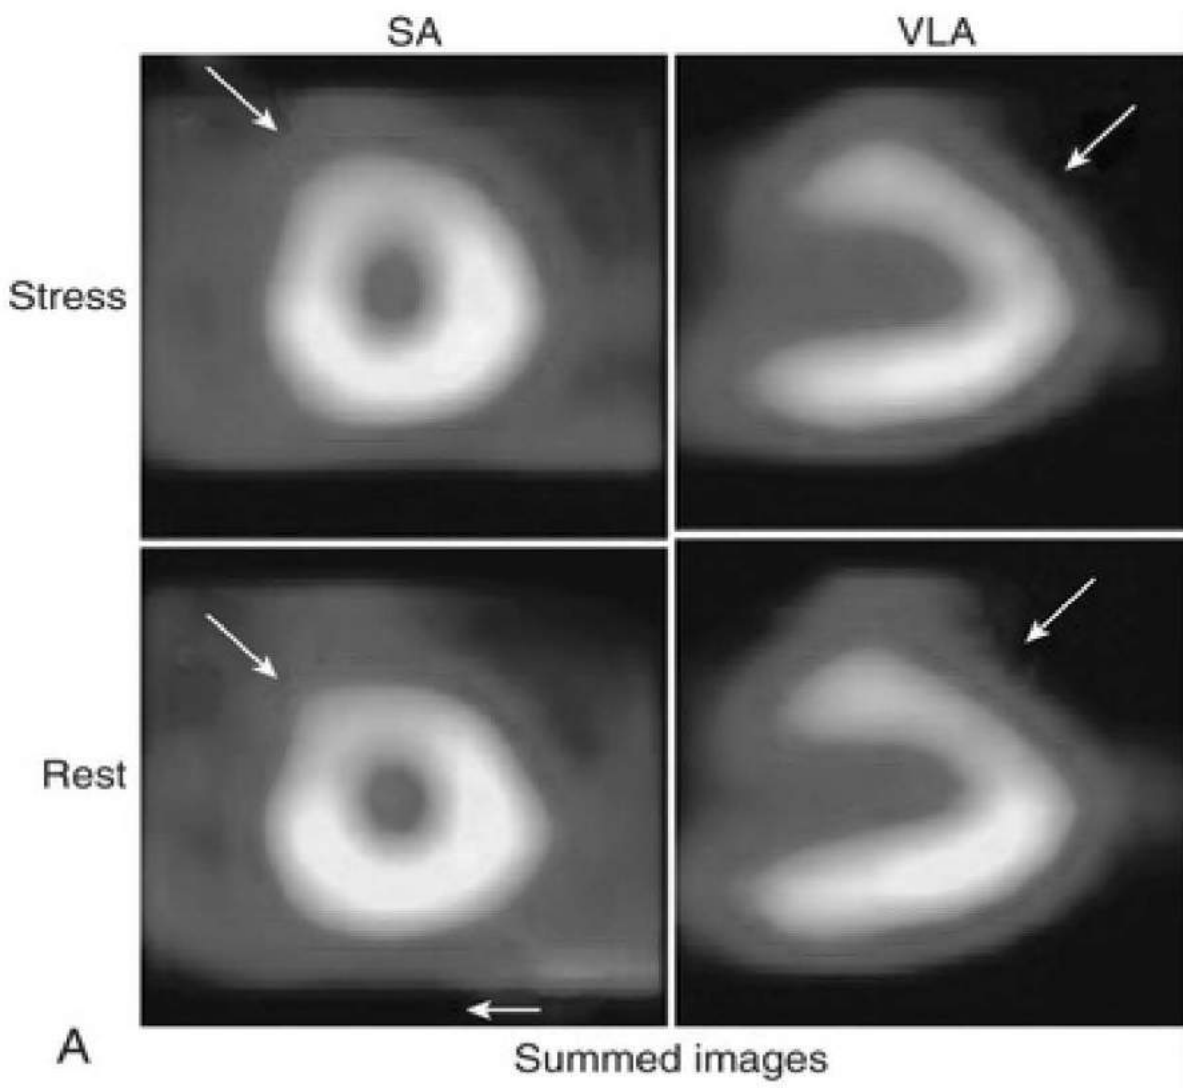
Differential diagnosis of a mild fixed defect by incorporation of gated functional images. A, The summed images demonstrate a mild fixed anterior and anteroseptal defect in the short-axis (SA) and vertical long-axis (VLA) views (*arrows*). There was a suggestion of breast shadowing on review of the raw cine images (not shown). Thus this defect may represent either a nontransmural anterior infarct or an artifact consistent with breast attenuation. In such cases, the gated SPECT functional images are helpful in making this distinction. B, In the gated images, the same SA and VLA views are shown but frozen in end diastole and end systole. In both views, wall thickening from end diastole to end systole (*arrows*) appears normal. This appearance is most consistent with an attenuation artifact, because an infarct would be expected to result in abnormal wall thickening.
